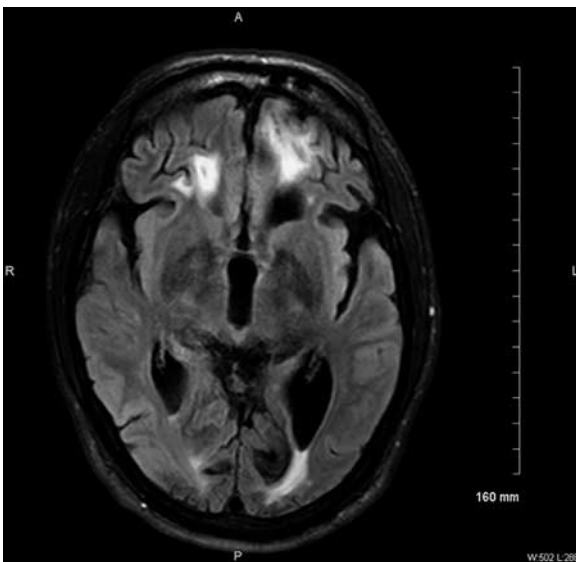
T1-weighted magnetic resonance imaging from the patient after injury revealed moderate lateral and mid-third ventricular dilation. Cystic changes, volume loss, and abnormal white matter were observed bilaterally in the frontal lobe. Abnormalities were noted in the left occipital lobe cortices and white matter.
